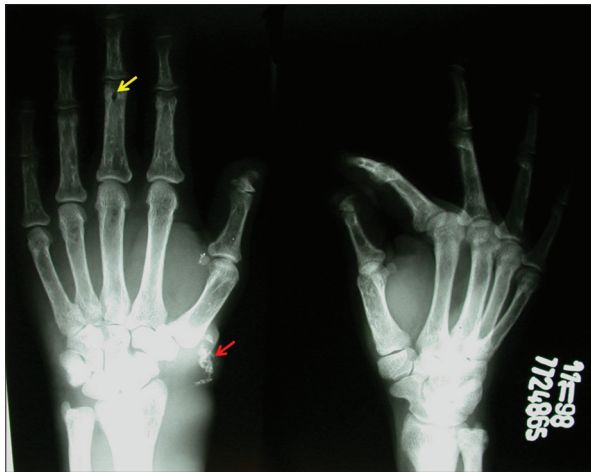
Radiograph showing metastatic calcifications in the joints (red arrow) and subperiosteal resorption of the phalanges (yellow arrow)
